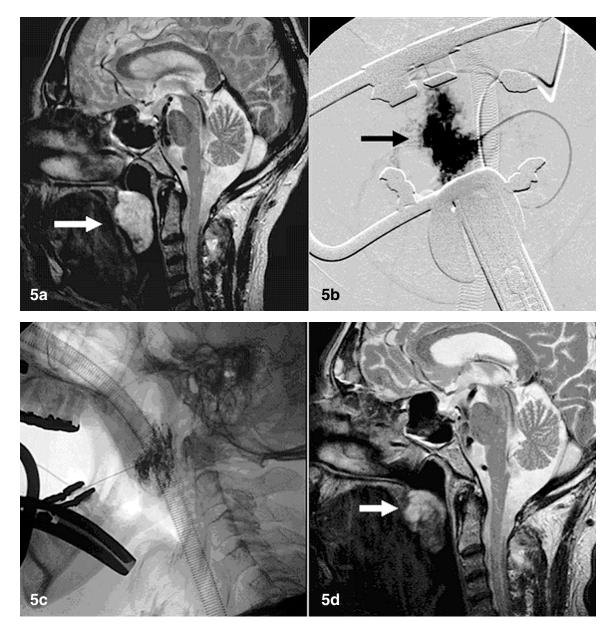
Pharyngeal venous malformation demonstrated by sagittal T2-weighted image before (arrow in a) and after the first treatment (d). Opacification of the lesion after injection of contrast medium (b - before and c - after first sclerosing treatment).
